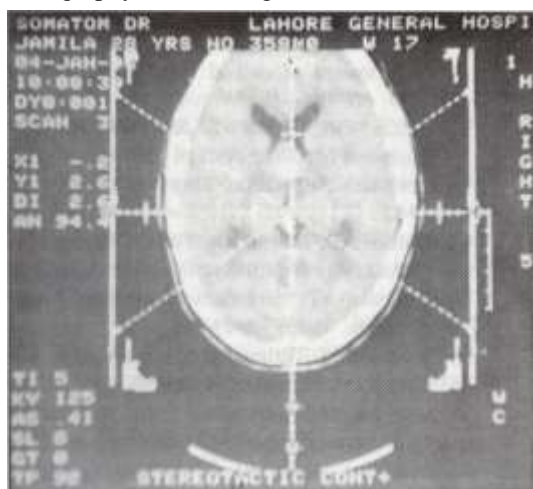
Target localization and calculation of coordinates assisted by CT after application of Leksell frame.
